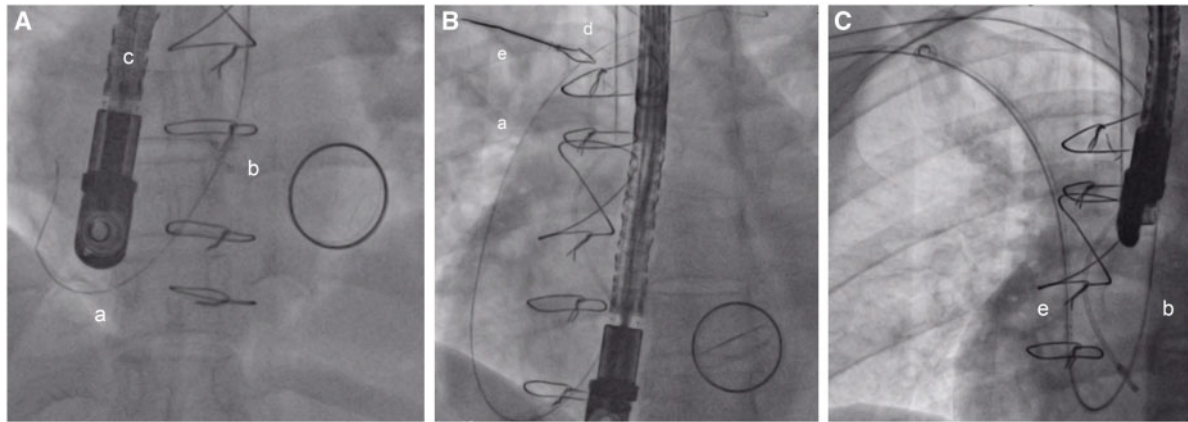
Probing of the fistula and creation of an arteriovenous loop. (A) Retrograde crossing of the aorto-atrial fistula using a guidewire (a) and a 5 Fr MP-II guiding catheter (b) under fluoroscopic and transoesophageal echocardiography (c) guidance. (B) Snaring (d) of the retrograde wire (a) via right basilic vein into a venous 6 Fr sheath (e). (C) Mother–child technique: the retrograde MP-II-guide catheter (b) is negotiated into the venous 6 Fr sheath (e).
